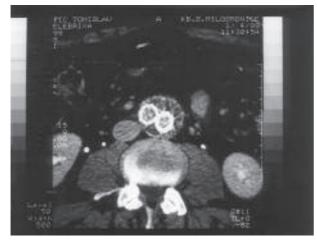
Patient 1 postoperative CT scan: right position of the iliac segment of the prosthesis; no endoleak was observed.
